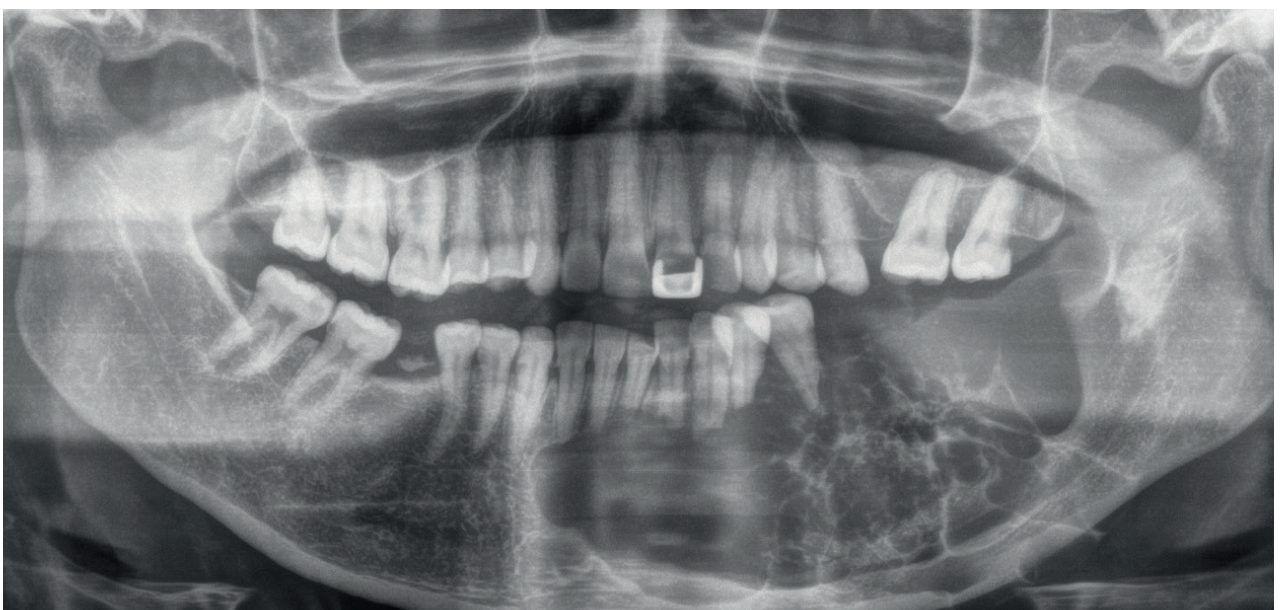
Panoramic radiograph of a multilocular lesion extending from the right to the left mandible. The lesion has resorbed and displaced the teeth in the mandible with a blunt appearance of the root apices. The lesion also displays a honeycomb appearance.
